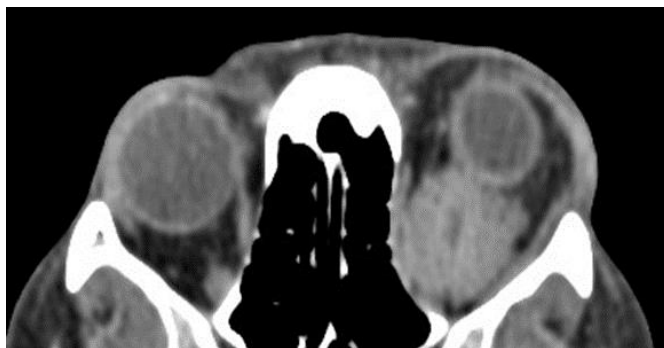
Patient S., 45-year-old, computed tomography scan fragment
